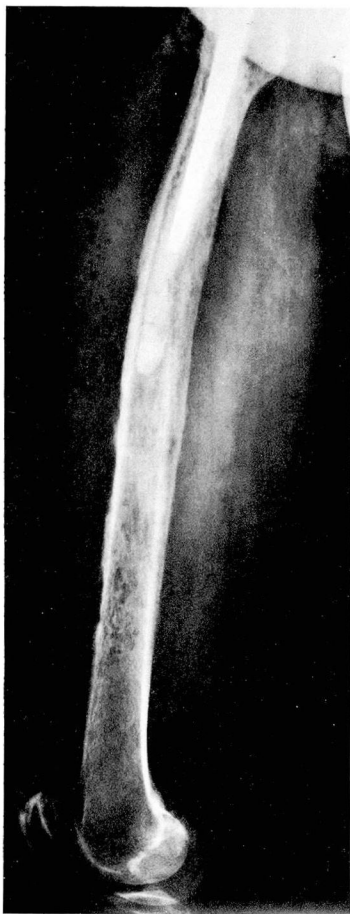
Lateral roentgenographic view of the right femur from the same patient as in *Figure 2*, taken 24 days after the onset of *Klebsiella* type 32 bacteremia. There is gas in soft tissues. The bony cortex is thinned and eroded and there are focal areas of periosteal reaction.
